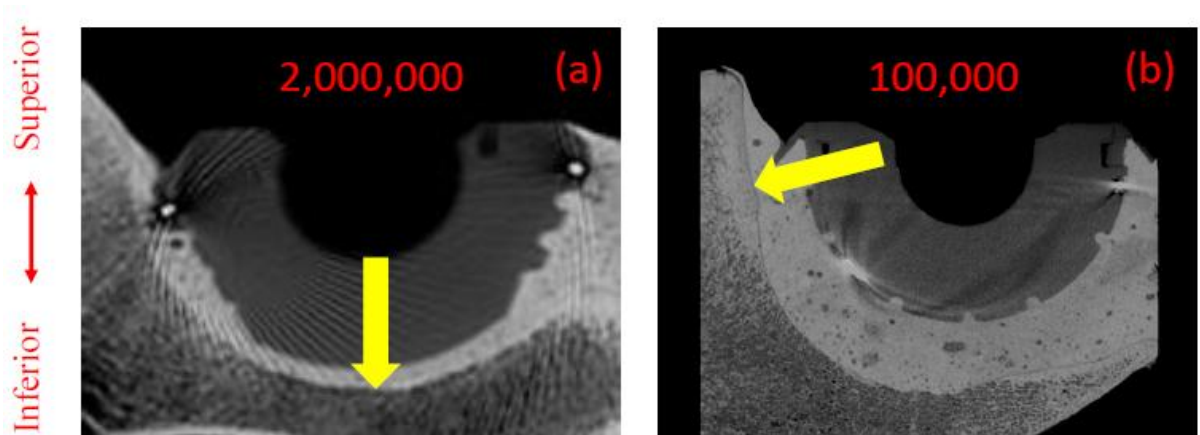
8: μ CT images from a mid-section for (a) an implanted hip tested under normal walking in dry conditions (Zant, 2006), where debonding developed near the dome region (DeLee & Charnley zone II) at about 2,000,000 cycles; (b) an implanted hip tested in wet conditions (current), where a demarcation may be observed in DeLee & Charnley zone I at just 100,000 cycles, as indicated by the arrows (Tozzi et al., 2012).
